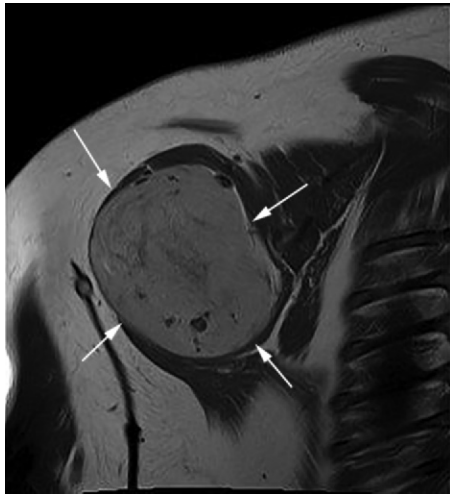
Hibernoma. Oblique coronal T1-weighted MR image shows a well-circumscribed mass (arrows) of the shoulder. The mass shows hyperintense signal that is less intense than that of the subcutaneous fat.
